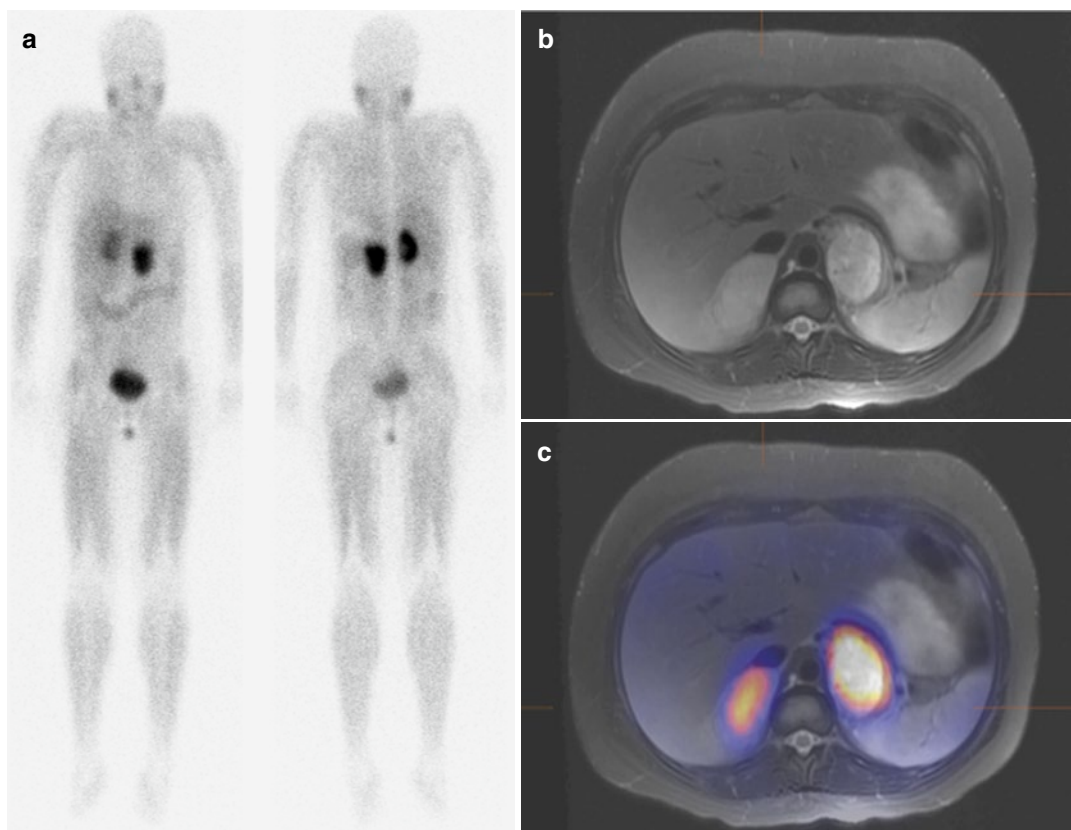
Bilateral pheochromocytomas identified by ^{123}I -MIBG scan. (a) An ^{123}I -MIBG whole-body scan in anterior and posterior projections shows intense focal uptake in both upper quadrants. (b) Correlative MRI demonstrates bilateral adrenal masses with heterogeneous T2
